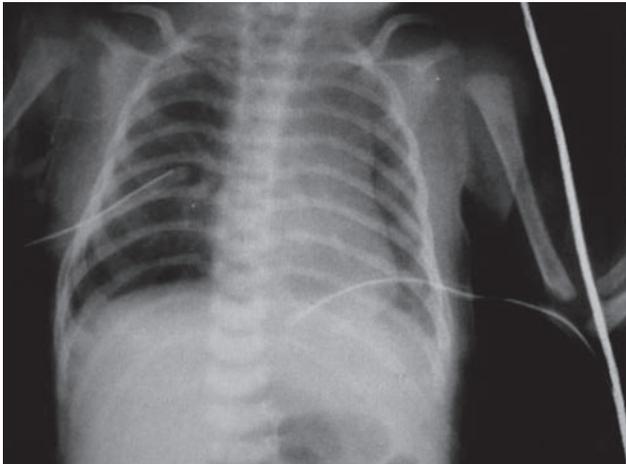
Chest X-ray confirmed that there was no pleural effusion.
